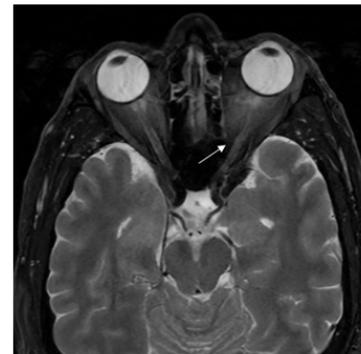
MRI Orbit showing asymmetric increased T2 signal and enhancement of the intraorbital segment of the left optic nerve (white arrow).
